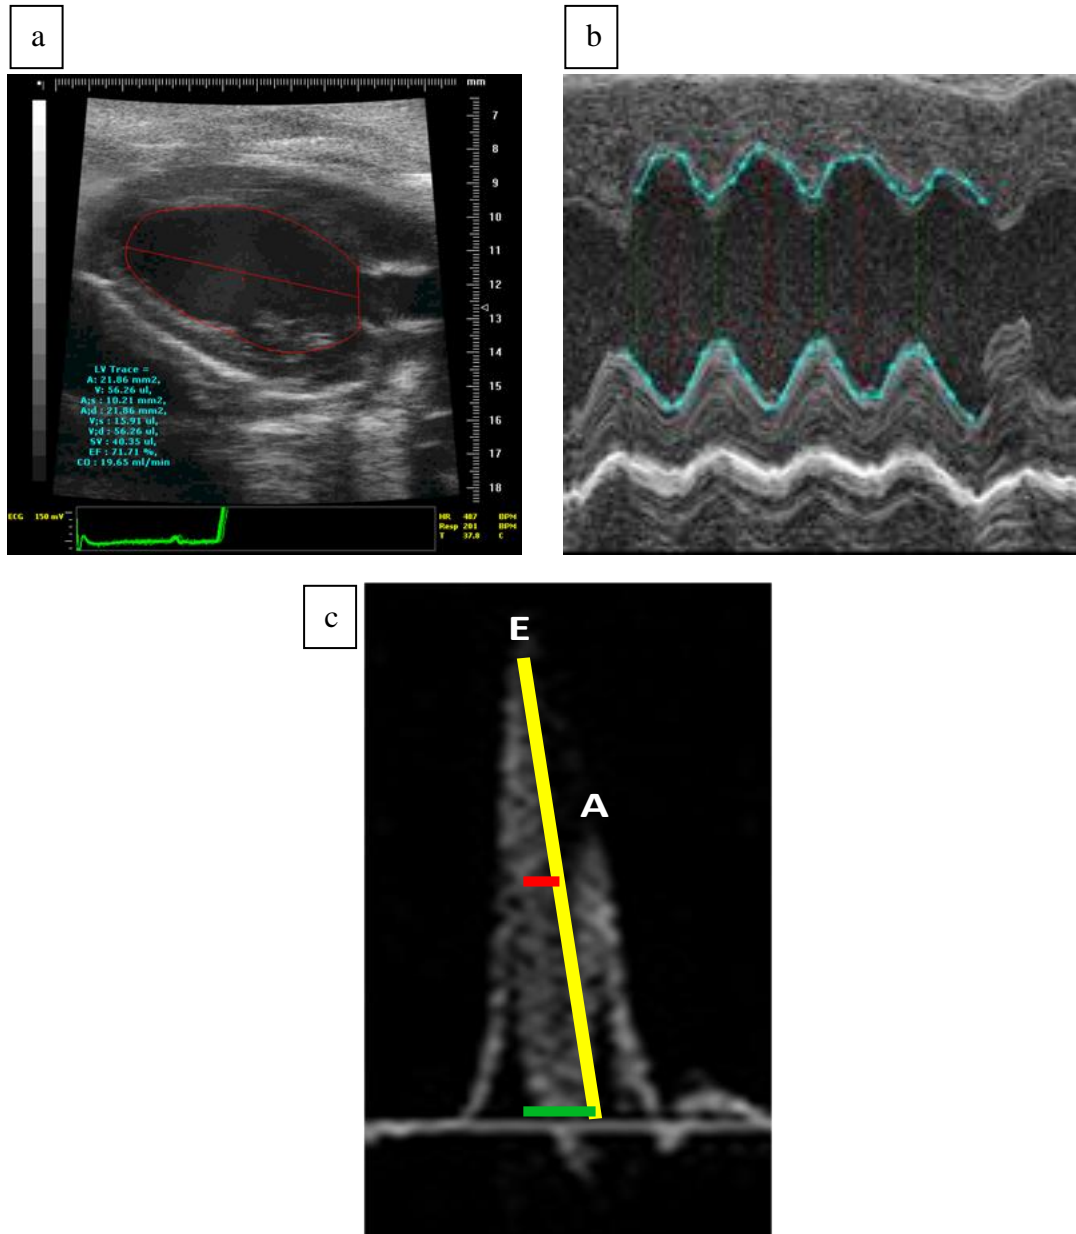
Echocardiography traces
